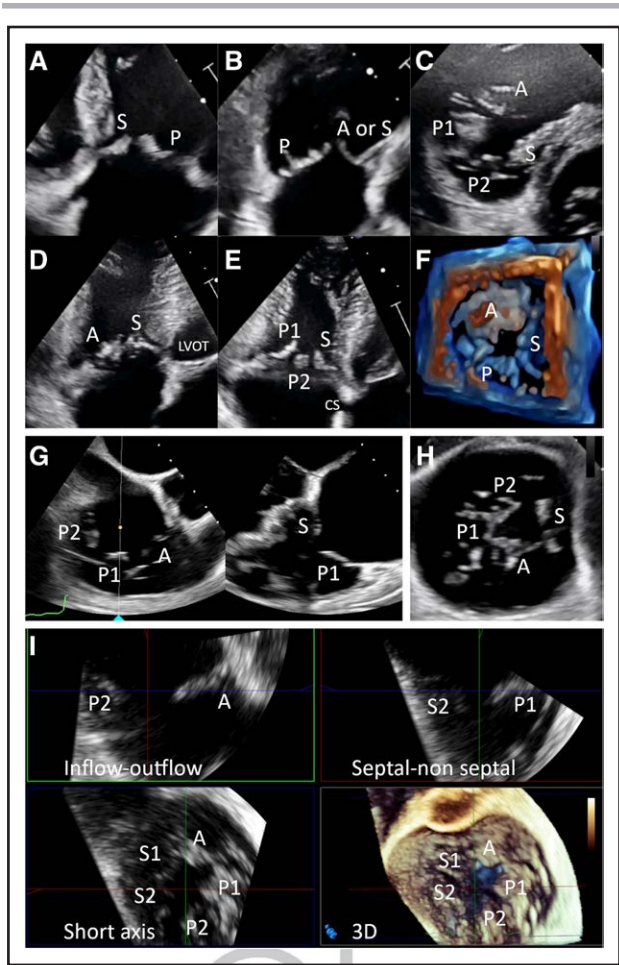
Tricuspid anatomy evaluation with TTE, TEE, and multiplanar reconstruction. A, Transthoracic echocardiography (TTE), right ventricular inflow with septum (S) in view. B, TTE, short-axis aortic valve level. C, TTE, short-axis en face view. D, TTE, apical 4-chamber view with anterior (A) focus, as demonstrated by the left ventricular outflow tract (LVOT) in view A-S. E, TTE, apical 4-chamber view with posterior (P) focus, as demonstrated by coronary sinus in view. P1 with tip of P2 in view (quadricuspid morphology). F, Three-dimensional TTE. G, Transesophageal echocardiography (TEE) biplane inflow-outflow across P1 showing P1-S in secondary view. H, TEE, transgastric en face view of quadricuspid tricuspid valve (TV). I, Multiplanar reconstruction of the TV (type IV).
